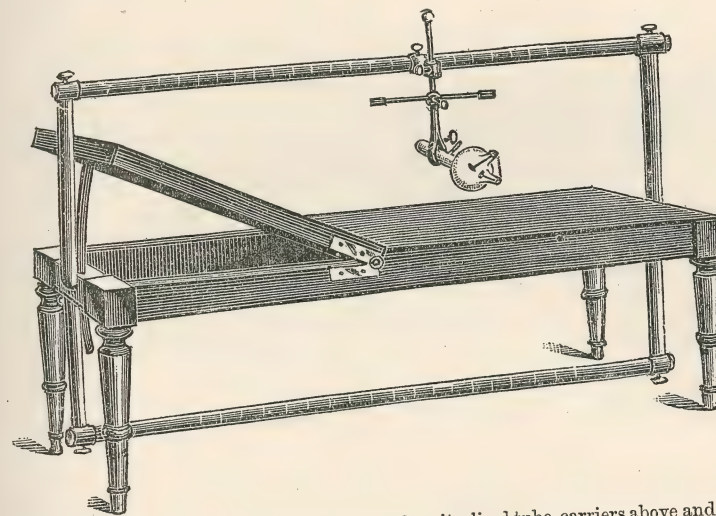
An X-ray examination table showing longitudinal tube-carriers above and below the patient. The jointed end can be raised or lowered to suit, the top is a thin, hard fibre which is transparent to the rays. Underneath and not seen in the cut is a traveling plate-holder for exposures with tube above patient.
